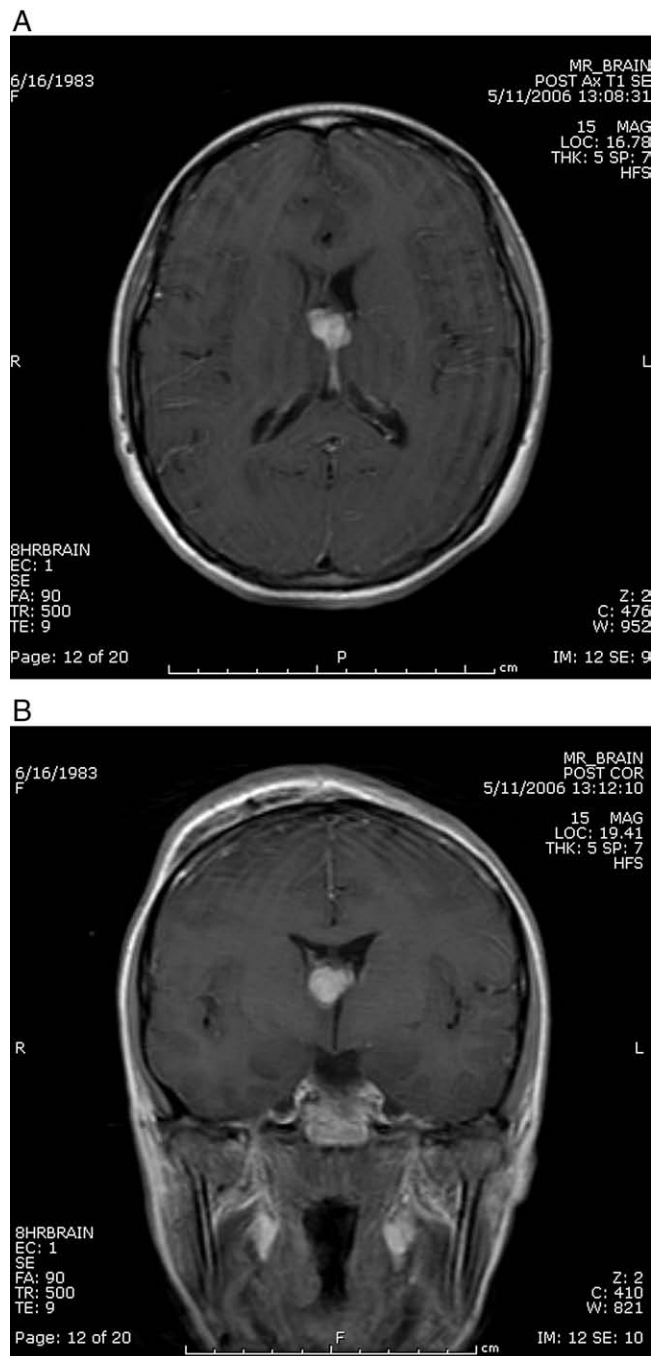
A (axial) and B (coronal): T1 MRI after gadolinium administration demonstrates an avidly enhancing mass near the right foramen of Monro.
